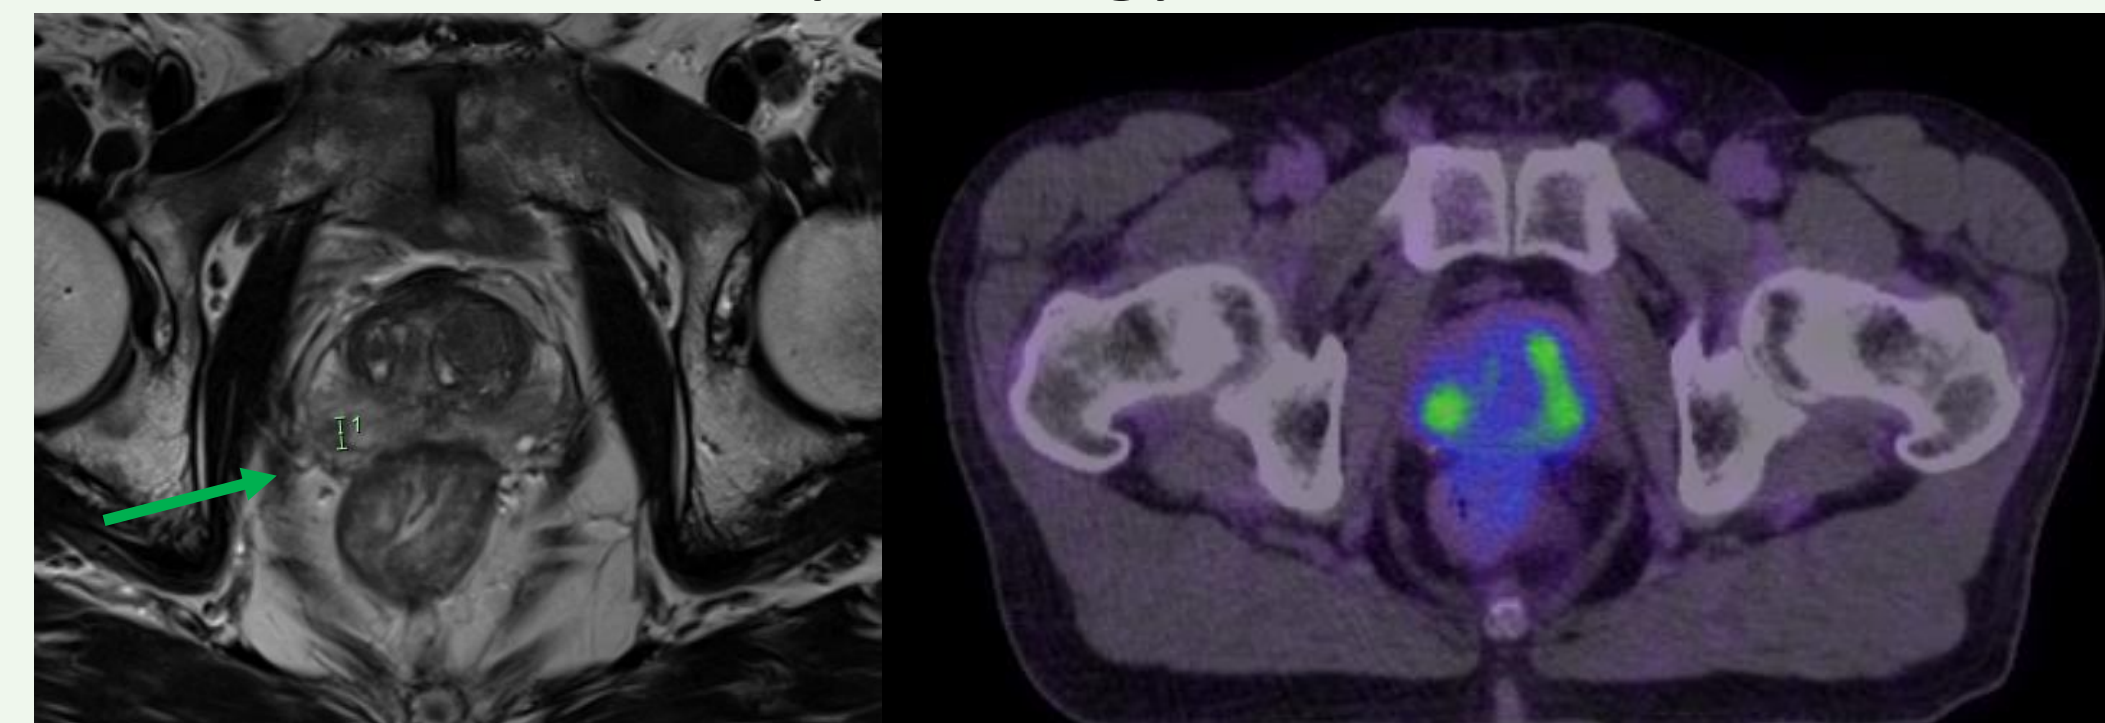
Example of missed out-of-field lesion, with focal lesion identified on T2 MRI imaging at right posterolateral peripheral zone, compared to multifocal PSMA uptake on PSMA PET
